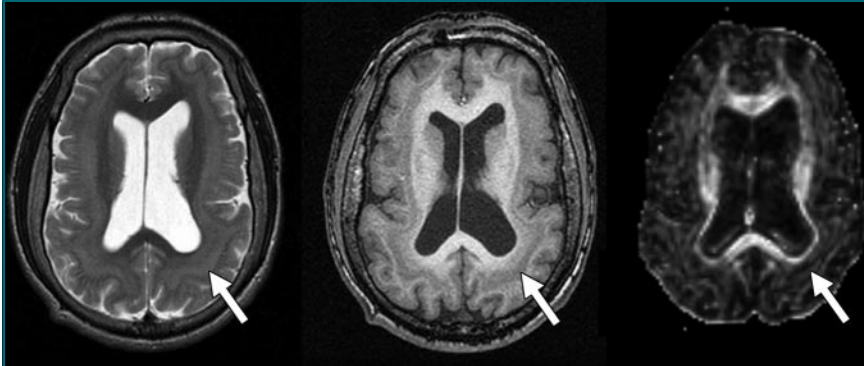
Images in 18-year-old woman with band heterotopia. Transverse T2-weighted (left) (4000/100; matrix, 352 × 352; FOV, 230 × 230 mm; section thickness, 5 mm) and T1-weighted (middle) (450/12; matrix, 256 × 256; FOV, 230 × 230 mm; section thickness, 5 mm) images demonstrate thick band heterotopia (arrow) with homogeneous signal intensity to gray matter, a so-called double cortex. This band shows high anisotropy (arrow) on fractional anisotropy map (right), suggesting its radial orientation and arrested neuronal migration (32 directions; six-channel sensitivity encoding; sensitivity encoding factor of two; *b* value, 600 sec/mm²; 6599–8280/70; matrix, 96 × 96; FOV, 220 × 220 mm; section thickness, 2.3 mm). It is also consistent with passage of intact white matter tracts through the abnormality.
